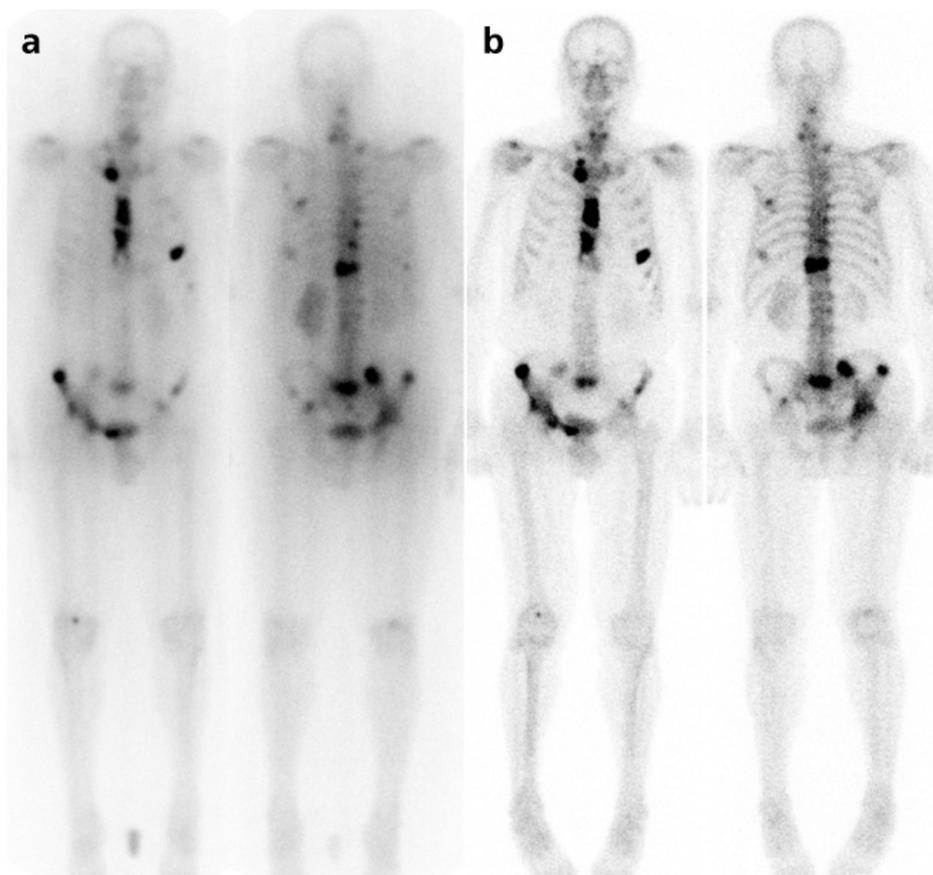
Post-treatment scintigraphy 6 hours after injection of 37 MBq/kg ^{188}Re -HEDP (anterior and posterior; 10% energy window around the peak of 155 keV, medium energy collimator, scan speed 6 cm per min.) (a) compared to pre-treatment skeletal scintigraphy 3 hours after injection of 600 MBq $^{99\text{m}}\text{Tc}$ -HDP (b)
